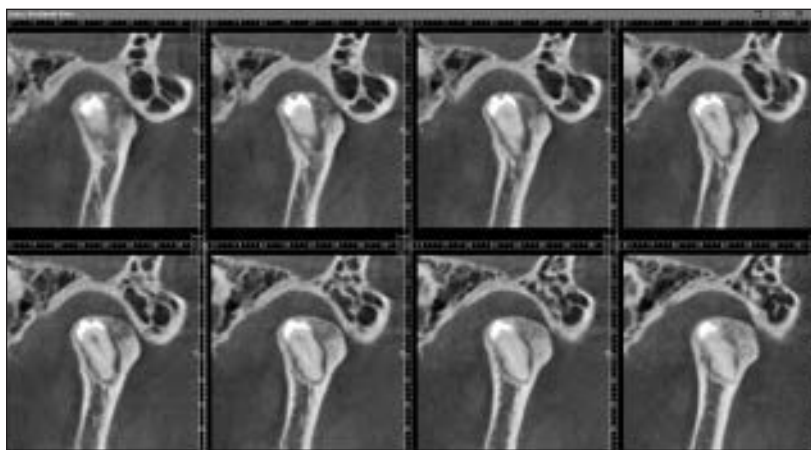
Cone beam computed tomography image: Radiopaque mass resembling a pre-molar tooth is visible in the mandibular condyle (InVivoDental, Anatomage).
